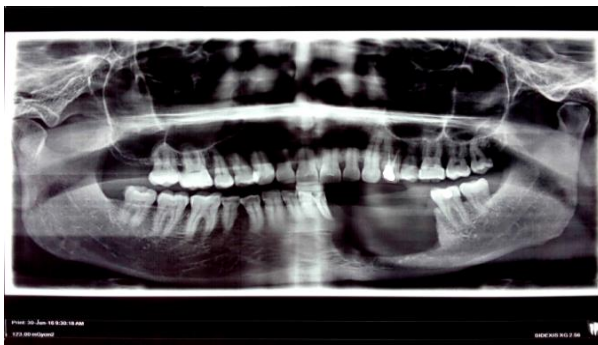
Orthopantomograph Showing Cantor And Curtis Class 1 Mandibular Defect.
